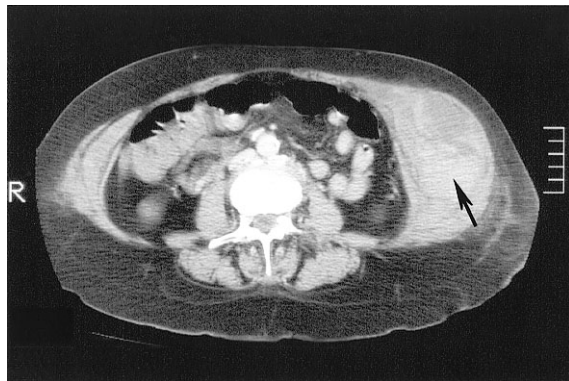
Abdominal CT scan demonstrating a large hematoma in the left abdominal wall (arrow) corresponding to the scintigraphic finding in the same region.
